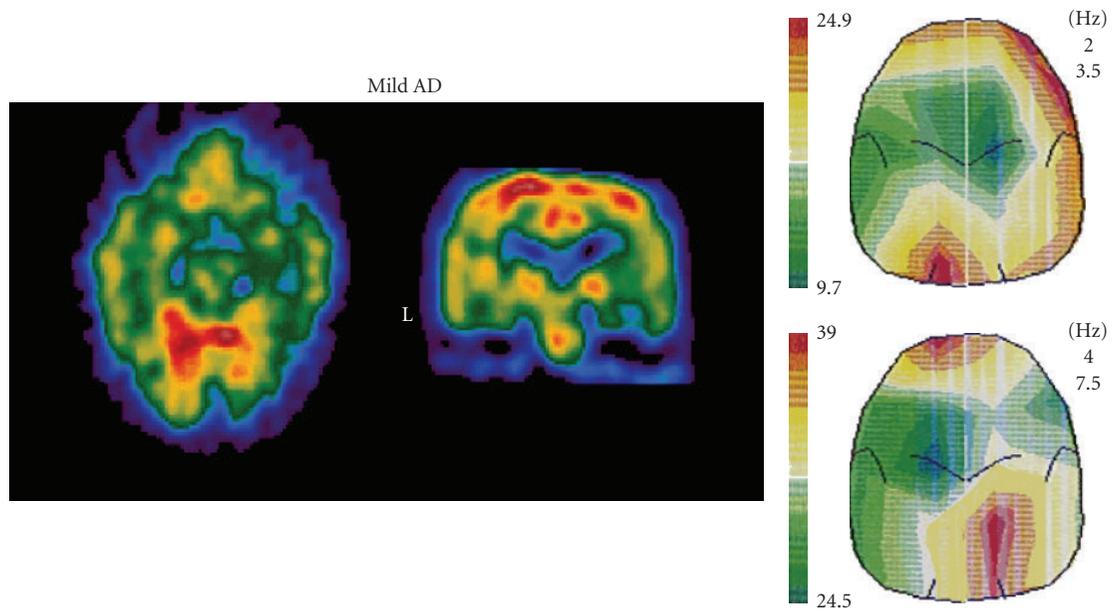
Sample of SPECT neuroimaging (Tc-99 HMPAO) and EEG brain mapping in a mild AD patient. Topographic scalp distribution of the EEG power on the 2.0 to 3.5 Hz frequency band (top right) and 4.0 to 7.5 Hz frequency band (bottom right) is shown. For more details, see text.
